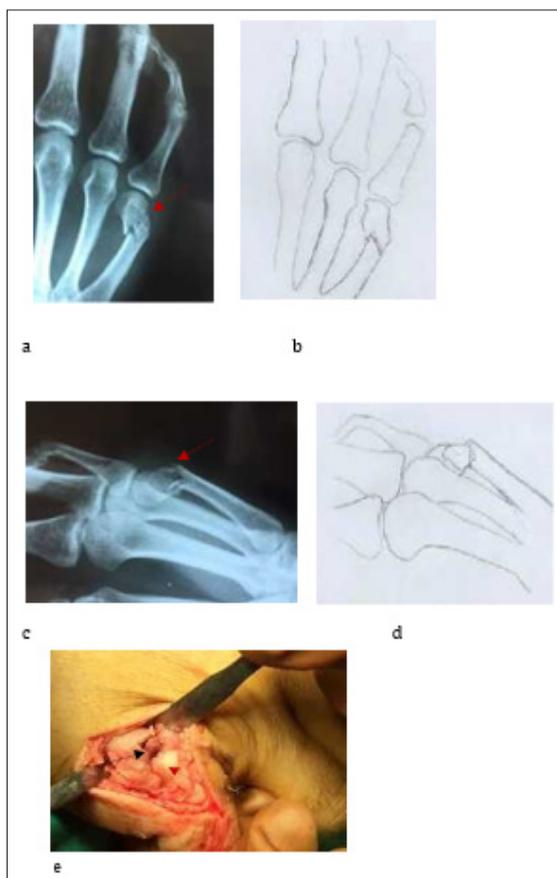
Type I fractures x-Rays (red arrow) AP (a,b), Oblique (c,d), (e) surgical evidence (dorsal comminution of neck - black arrow, head of metacarpal red arrow).
